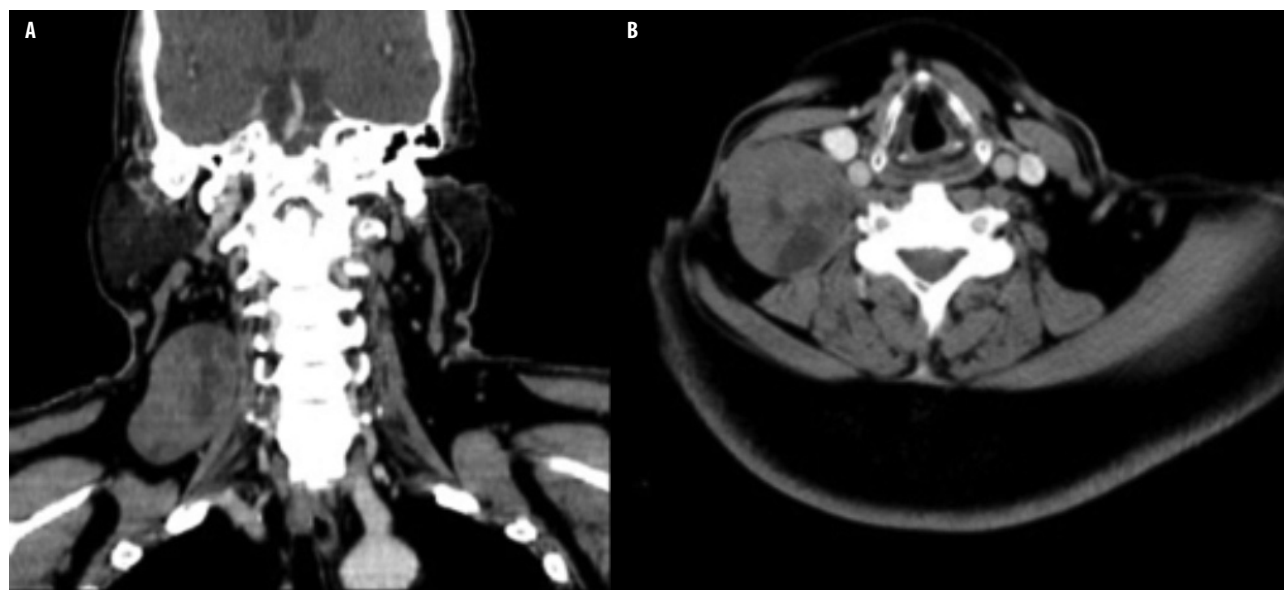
Axial view (A) and coronal view (B) of preoperative CT scan showing a soft tissue mass measuring 5 × 4.6 × 7 cm, with necrotic changes at the right lateral neck
